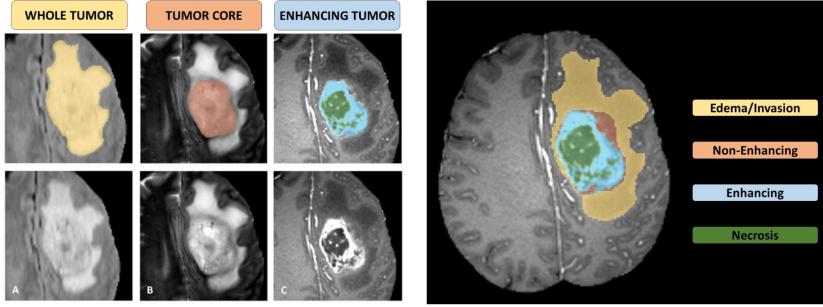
Images with the tumor sub-regions annotated in the different MRI modalities. The image patches show from left to right: the whole tumor (yellow) visible in T2-FLAIR (Fig. A), the tumor core (orange) visible in T2 (Fig. B), the enhancing tumor (light blue) visible in T1-Gd, surrounding the necrotic components of the core (green) (Fig. C)[8].Figure taken from [8].
